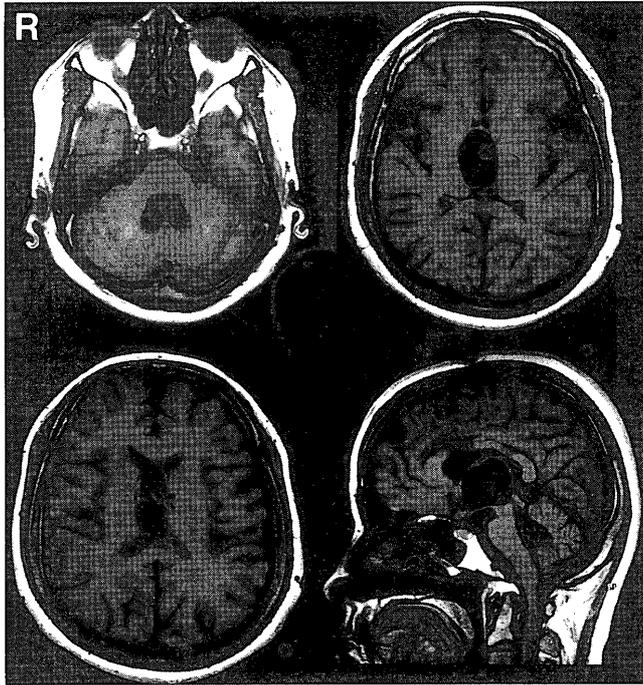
Preoperative magnetic resonance images showing isolated dilation of the third and fourth ventricles.
